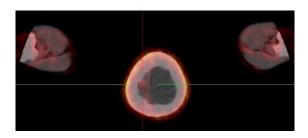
⁶⁸Ga-PSMA PET/CT scan –skull, showing a mass in the right parieto-temporal region, which has low SUV(SUV max=1.83).
